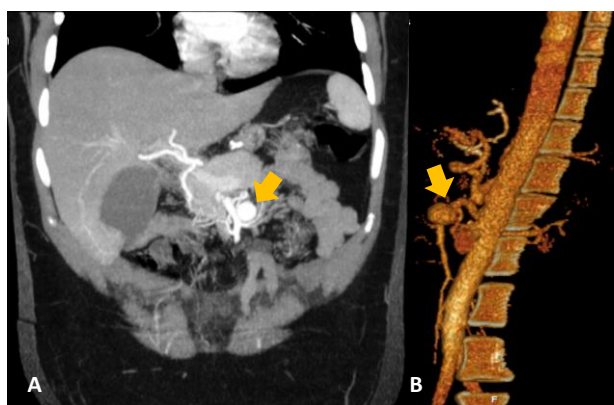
Angio CT revealing SMAA (arrows) (A) coronal view; and (B) sagittal view.
